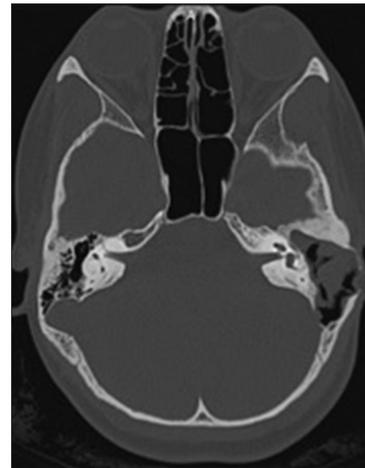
Axial HRCT image shows soft tissue density mass in the left middle ear cavity, aditus, and antrum with the erosion of the sigmoid sinus plate and lateral cortical wall of the mastoid. Mastoid septae are eroded forming single cavity on left side
